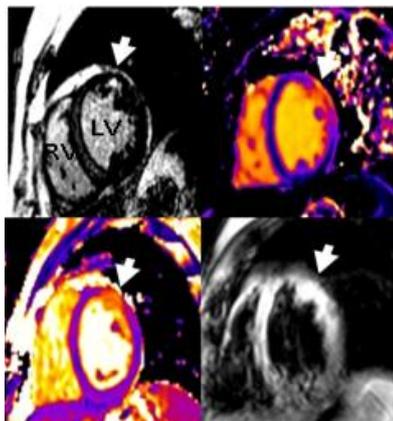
MRI findings in a 48year old male patient post PCI for NSTEMI. (A=LGE; B=T1; C=T2; D=T2 STIR). Anterolateral subendocardial infarction, as revealed by LGE, corresponds with transmural oedema revealed with T1, T2 and T2 STIR.
